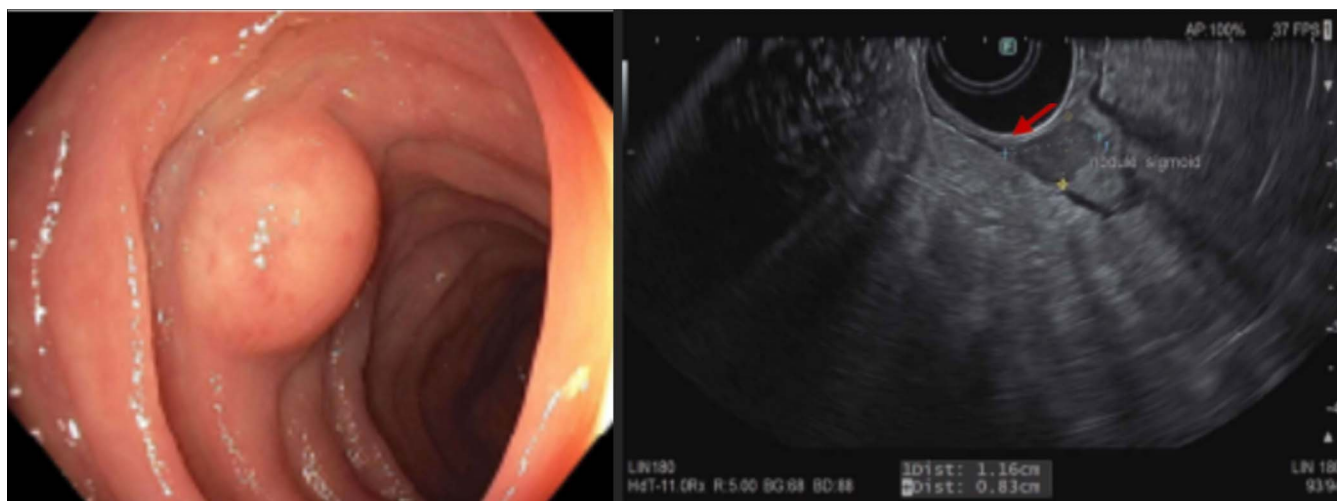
Colonoscopy image showing the subepithelial lesion in the sigmoid colon (blue arrow), and endosonographic appearance of the lesion originating from muscularis propria (red arrow).
